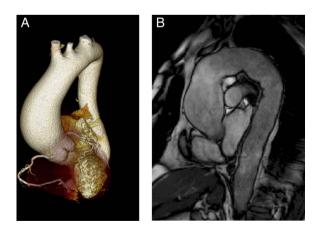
Imaging the aorta using CT and cardiac MRI (CMR). On the left is a reconstructed three-dimensional-rendered CT scan of the heart with a dilated ascending aorta and on the right is a steady-state free precession (SSFP) image on CMR of a moderately dilated ascending aorta.
